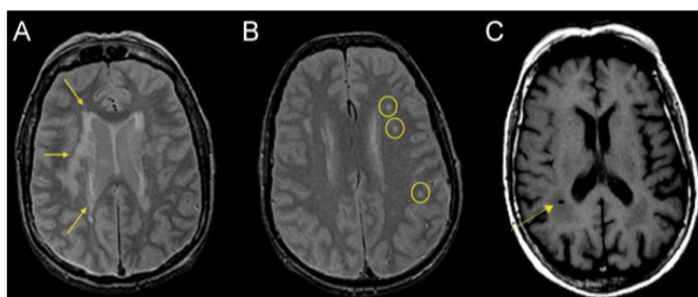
Silent brain infarct and white matter lesions in participants of the Rotterdam Study at baseline. Vascular brain changes on 1.5 T MRI are shown. Arrow indicates the abnormality in the image. (A) Periventricular white matter lesions on T2 weighted sequence. (B) Subcortical white matter lesions on T2 weighted sequence. (C) Lacunar infarct on T1 weighted sequence.
